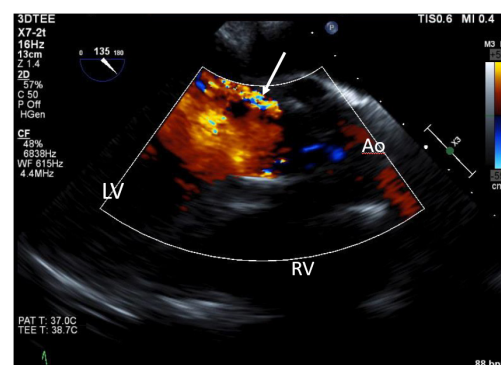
Transesophageal echocardiogram demonstrates aortic regurgitation (arrow). LV, the left ventricle; RV, the right ventricle.
